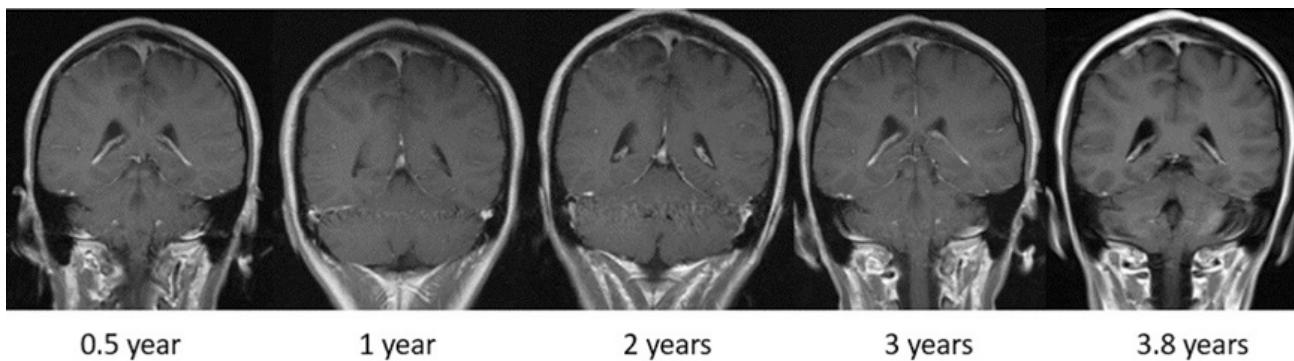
Enhanced cranial MRI was performed after surgery with no visible abnormal changes.
